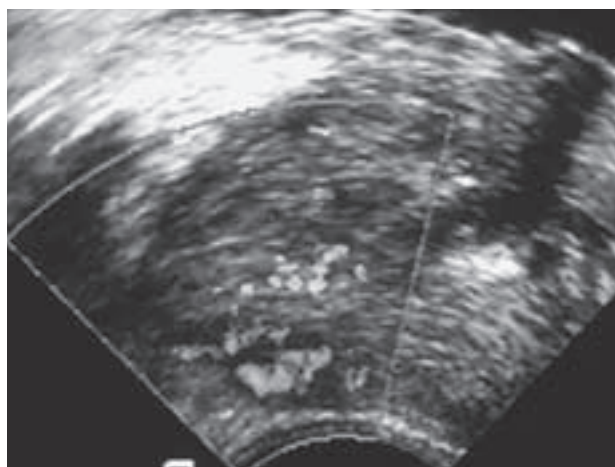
Color Doppler transrectal ultrasound image in a patient with prostate cancer demonstrates a hypoechoic lesion in the right peripheral zone of the prostate, with marked vascularity.
